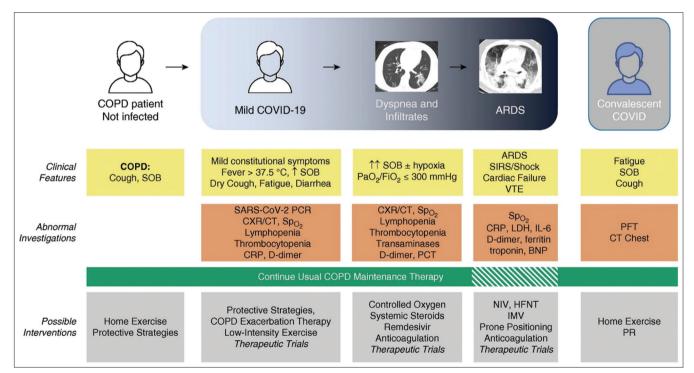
Clinical features and abnormal investigations shared among COPD patients infected with SARS-CoV-2, along with possible interventions. COVID-19=coronavirus disease; COPD=chronic obstructive pulmonary disease; SOB=shortness of breath; ARDS=acute respiratory distress syndrome; SIRS=systemic inflammatory response syndrome; VTE=venous thromboembolism; CXR=chest radiograph; CT=computed tomography; SpO<sub>2</sub>=peripheral oxygen saturation; CRP=C-reactive protein; LDH=lactate dehydrogenase; PCT=procalcitonin; BNP=brain natriuretic peptide; PFT=pulmonary function tests; NIV=non-invasive ventilation; HFNT=high-flow nasal therapy; IMV=invasive mechanical ventilation; PR=pulmonary rehabilitation; reproduced under the terms of Creative Commons Attribution Non-Commercial No Derivatives License 4.0 citing [28]
